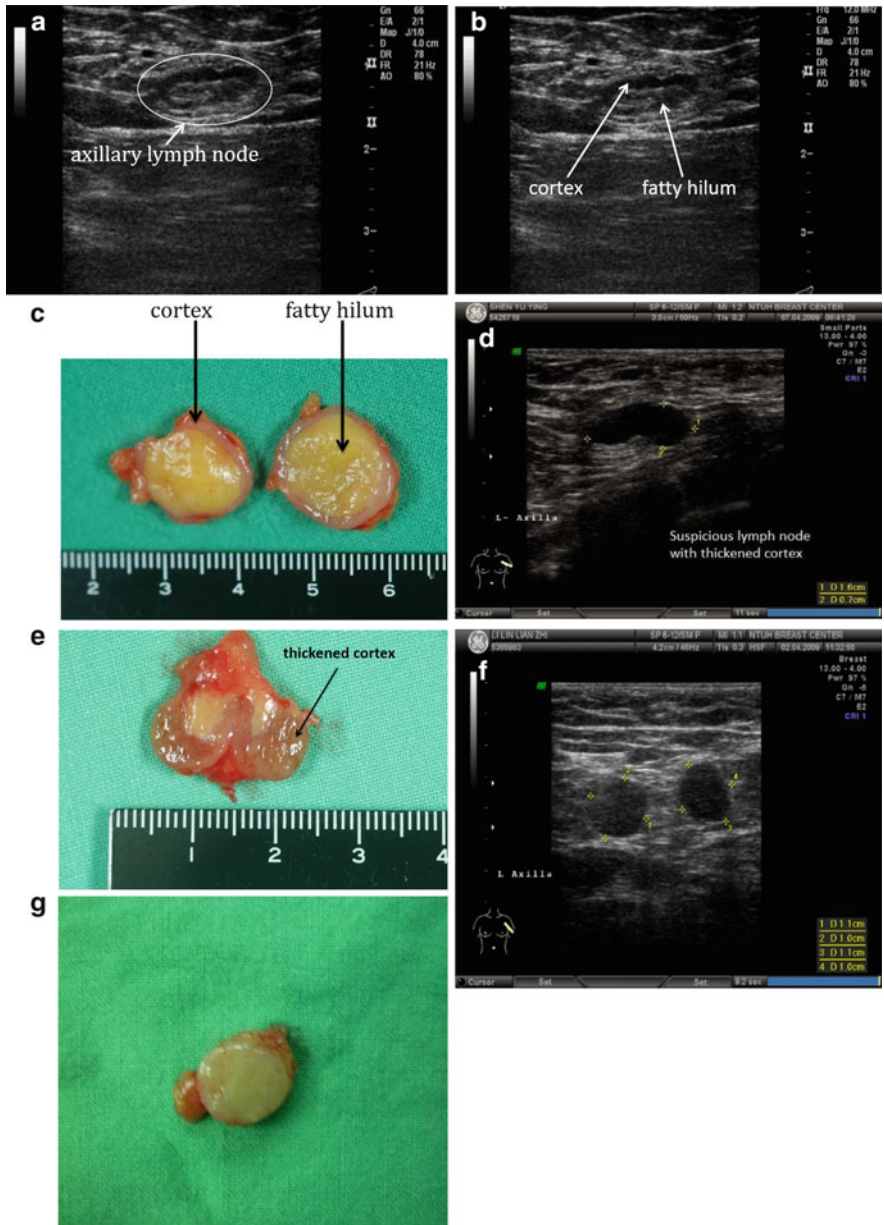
Ultrasound images and photos of benign and suspicious axillary lymph nodes (a) A benign lymph node on AUS with thin cortex (b) Benign lymph node on AUS (c) Cut surface of a benign lymph node (d) A suspicious lymph node with thickened cortex (7 mm) (e) Cut surface of a lymph node with thickened cortex (f) A metastatic lymph node characterized by loss of the fatty hilum with rounding appearance (g) Cut surface of a metastatic lymph node
